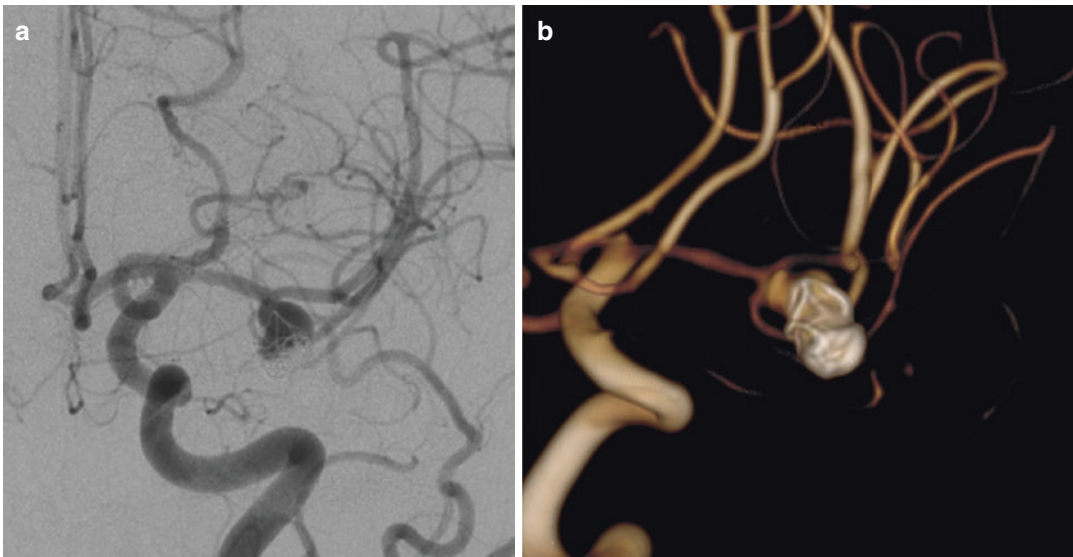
Recurrent endovascularly treated middle cerebral artery aneurysm shown in (a) AP angiographic view and (b) reconstructed CT angiography
